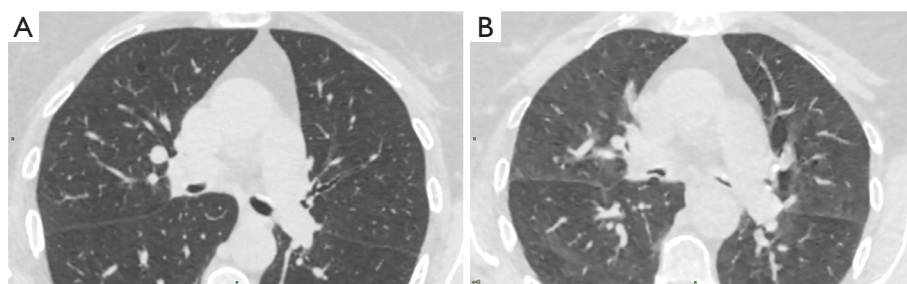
Thoracic CT scan, transverse section, non-injected, parenchymal window. Dynamic sections in inspiration (A) and expiration (B), showing a bronchial collapse during expiratory time, signaling a bronchomalacia. CT, computed tomography.
